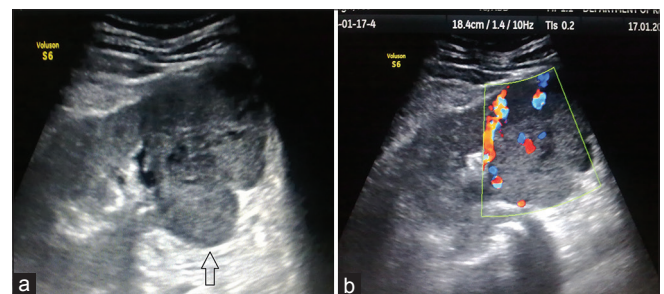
(a) Grayscale sonography image of the left kidney in longitudinal axis showing a well-defined, lobulated, hypoechoic mass lesion arising from the lower pole. (b) Color Doppler mode showing vascularity in the mass
